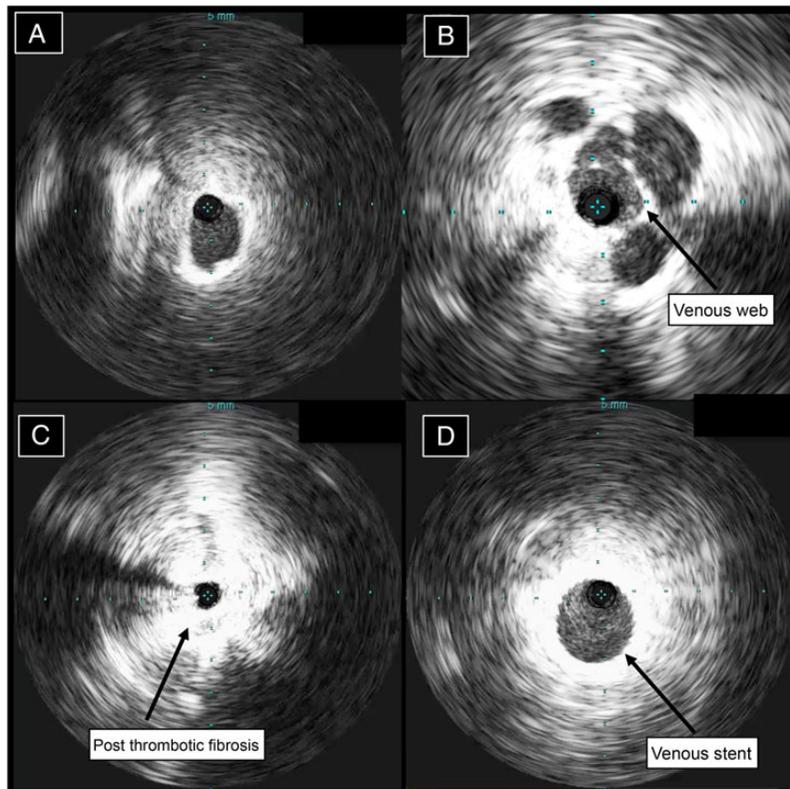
Intravascular ultrasound (IVUS). (A) Appearance of normal vein, (B) appearance of 'webs' in a post-thrombotic vein, (C) appearance post thrombotic venous segment (now traversed with a wire) before stenting, (D) appearance of a venous stent in a previously occluded segment.
